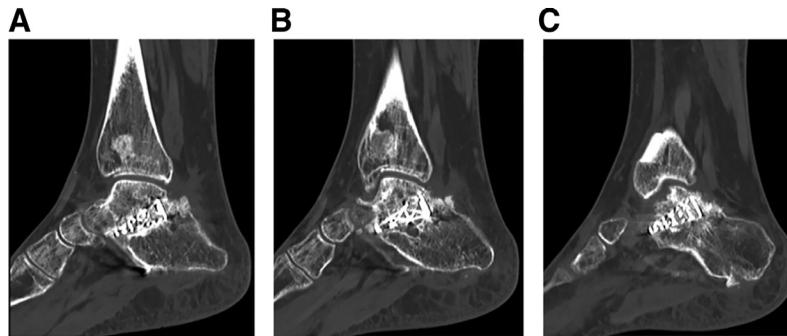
Postoperative computed tomographic scan revealing incorporation of bony ingrowth into the titanium truss (A–C) lateral to medial.
